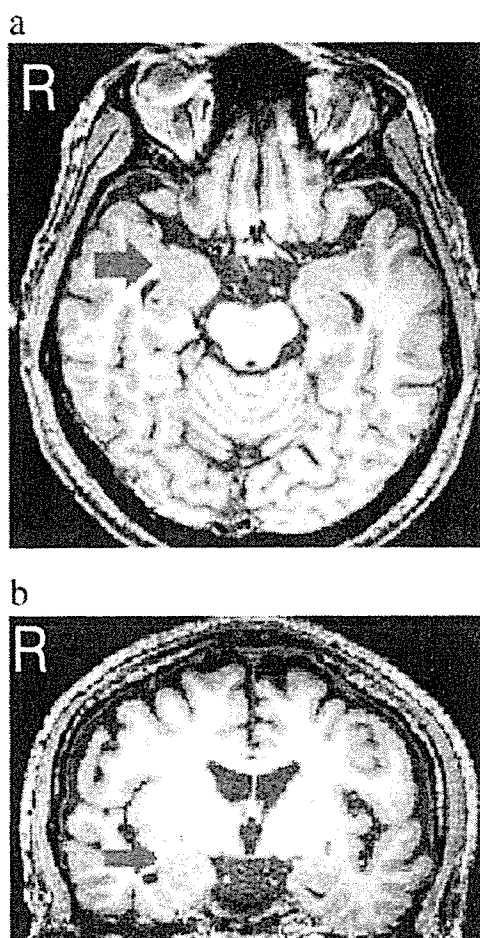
T1-weighted MRI images. Right amygdalar enlargement was found in the axial (a) and the coronal (b) images. Arrow shows the enlarged amygdala.
